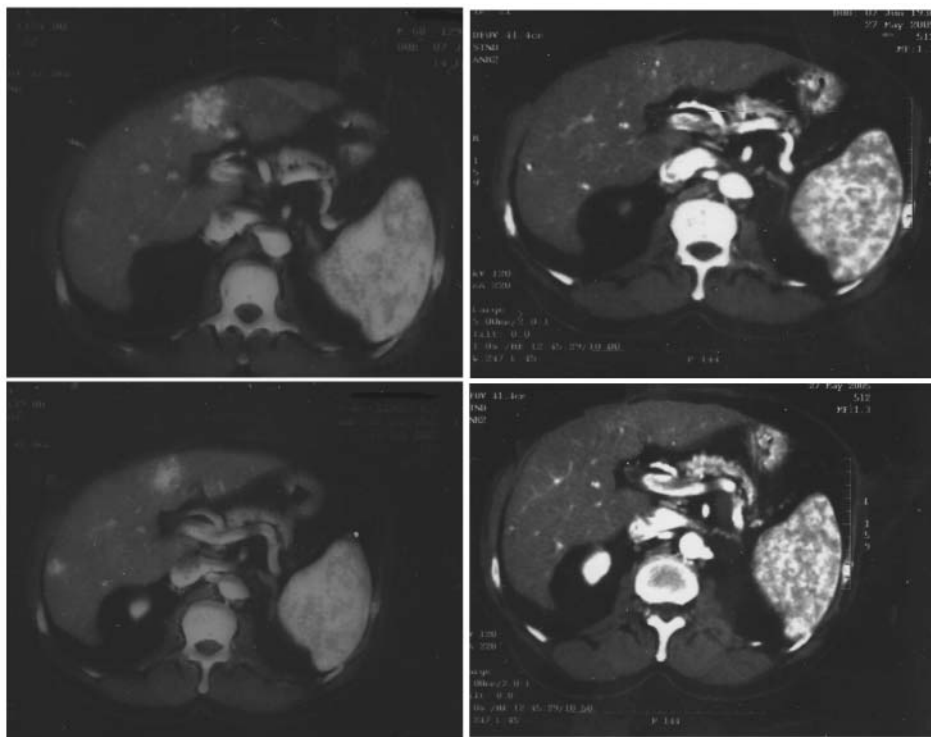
CT scan of the liver at baseline (left) and after 2 cycles of therapy (right) in patient C.
